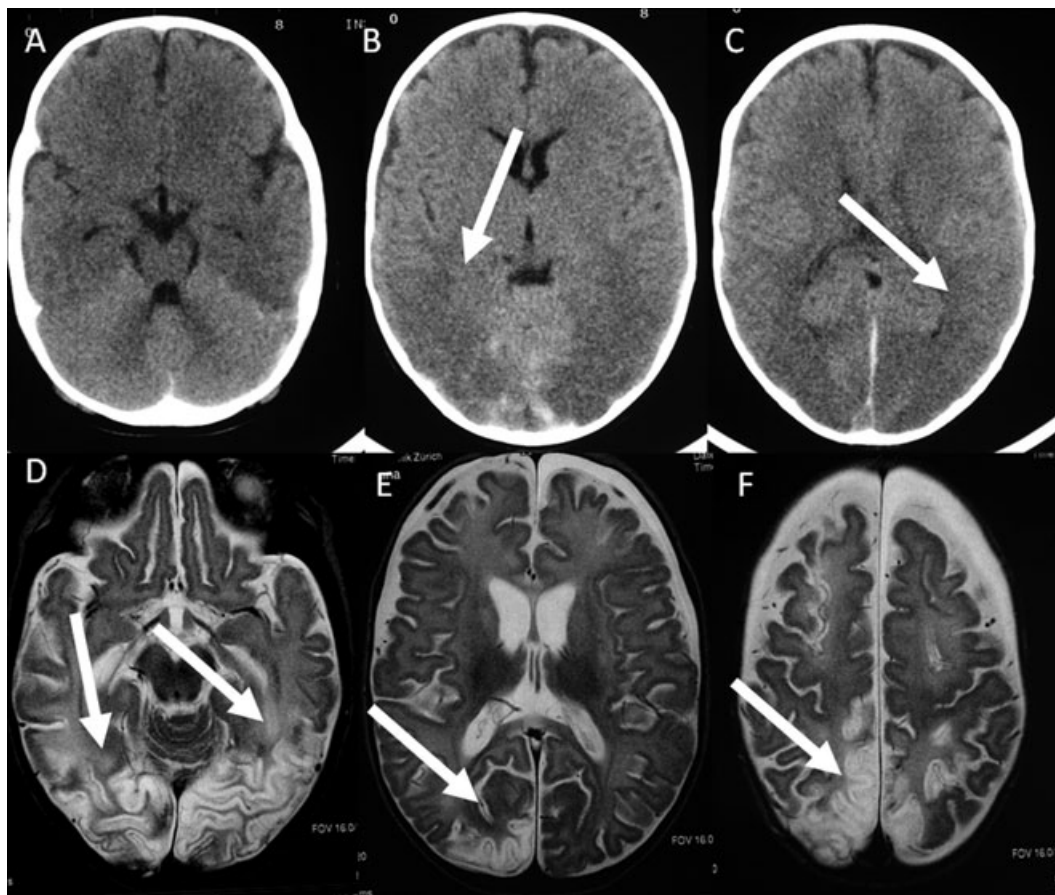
Acute axial CT (A–C) and follow-up T2-weighted (D–F) MR images of a child who suffered from nonaccidental injury with simultaneous strangulation. The supratentorial brain is edematous (hypodense, arrows) relative to the preserved cerebellum (white cerebellar sign) suggesting global brain edema (A–C). Hyperdense subdural blood is seen along the falx and tentorium. Follow-up MRI (D–F) shows extensive global and partially focal tissue loss. The occipital lobes and hippocampi are predominantly injured with laminar necrosis. The CSF spaces are diffusely widened because of global tissue loss.
